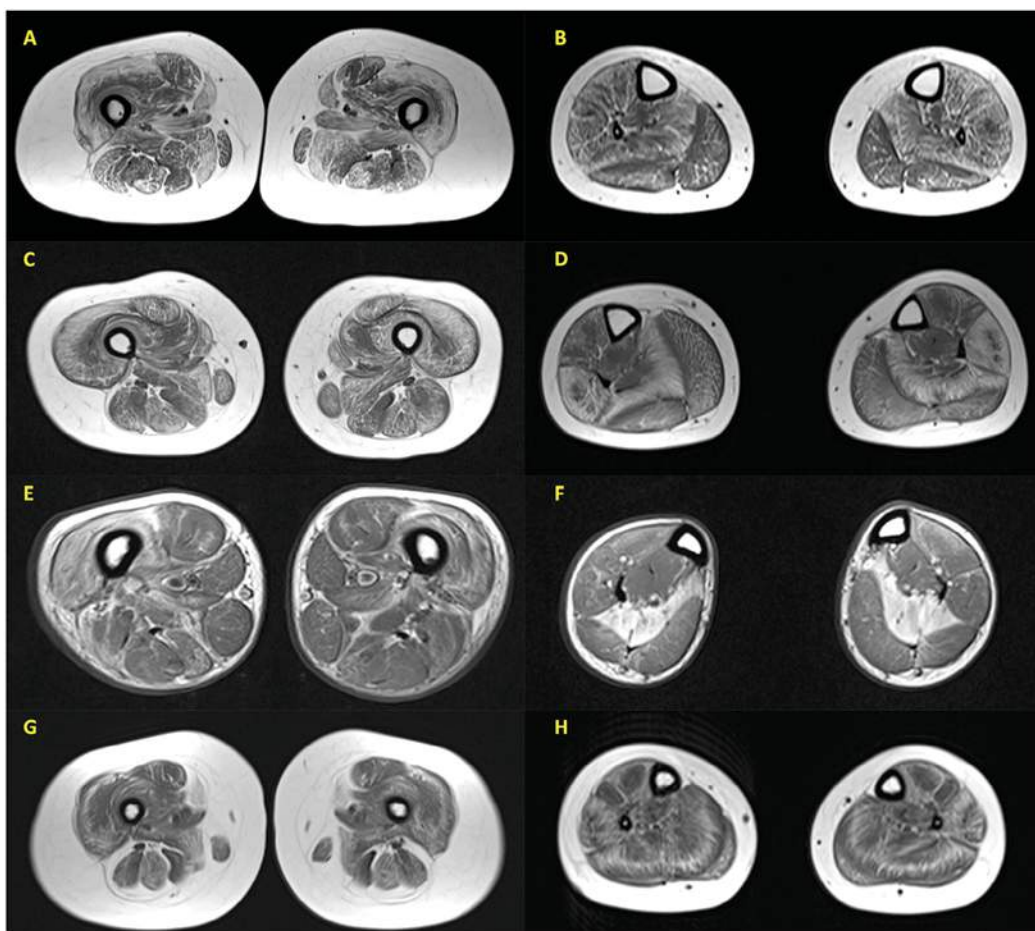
MRI imaging of the lower limbs of *RYR1*-related CNM patients. At the level of the thighs, in the four patients shown, vastus lateralis is selectively more affected than the rectus femoris (A, C, E, and G). At the level of the legs, anterior and posterior compartments seemed to be affected in a similar degree, but the soleus muscle was selectively more involved in a few patients (D, F). T1-weighted FSE sequence MRI at the level of the thighs (A, C, E, G) and legs (B, D, F, H); patients B.1 (A, B), B.2 (C, D), D.1 (E, F) and G.1 (G, H).
